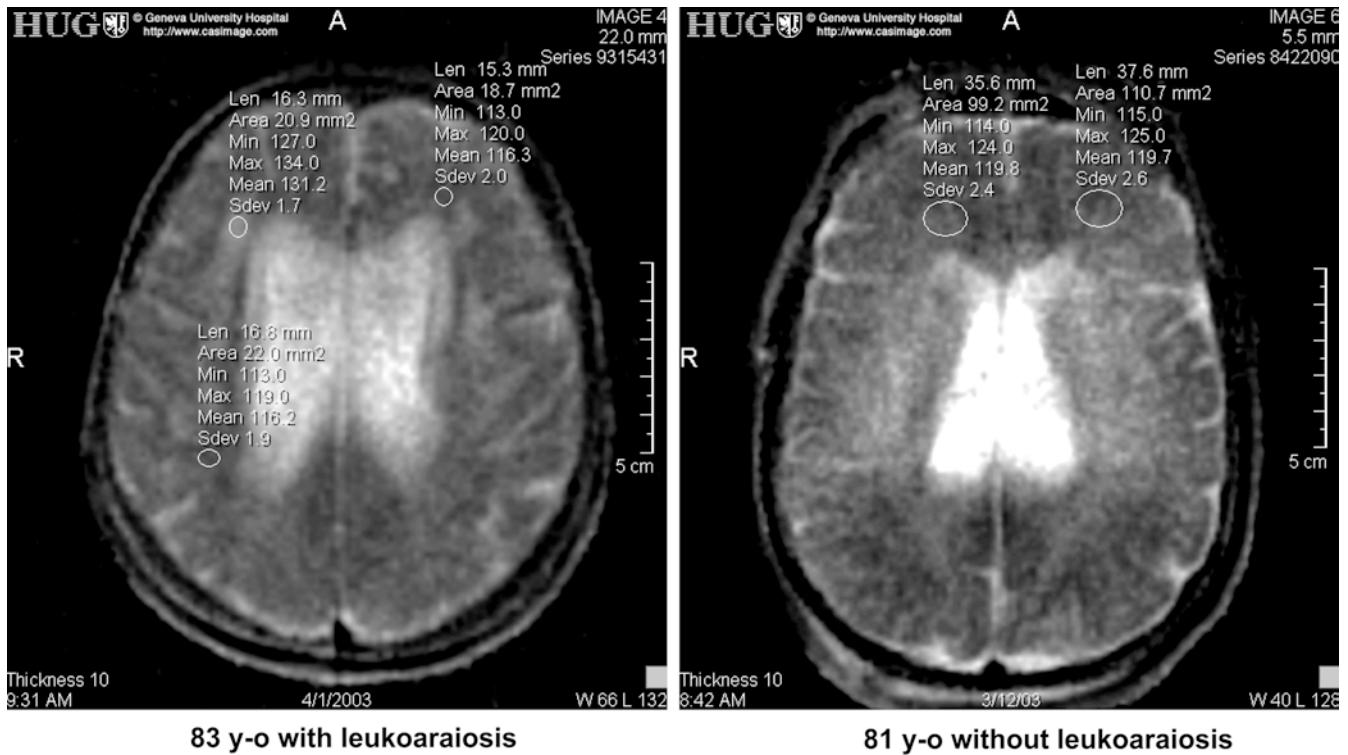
Two elderly patients with slight cognitive impairment: on the left side an 83-year-old patient with T2-weighted leukoaraiosis, on the right an 81-year-old patient without leukoaraiosis. When measuring ADC values in the leukoaraiotic areas in the frontal lobes we found that in the high T2-weighted hyperintensity (*right*) there are higher ADC values ($1.34 \times 10^{-3} \text{ mm}^2/\text{s}$) in the left frontal lobe of the patient with leukoaraiosis than in the less affected areas (contralateral frontal white matter: $1.16 \times 10^{-3} \text{ mm}^2/\text{s}$, or homolateral parietal white matter: $1.16 \times 10^{-3} \text{ mm}^2/\text{s}$); or compared with the elderly patient of slightly younger age with no leukoaraiosis ($1.19 \times 10^{-3} \text{ mm}^2/\text{s}$ in both the white matter in both frontal lobes)
